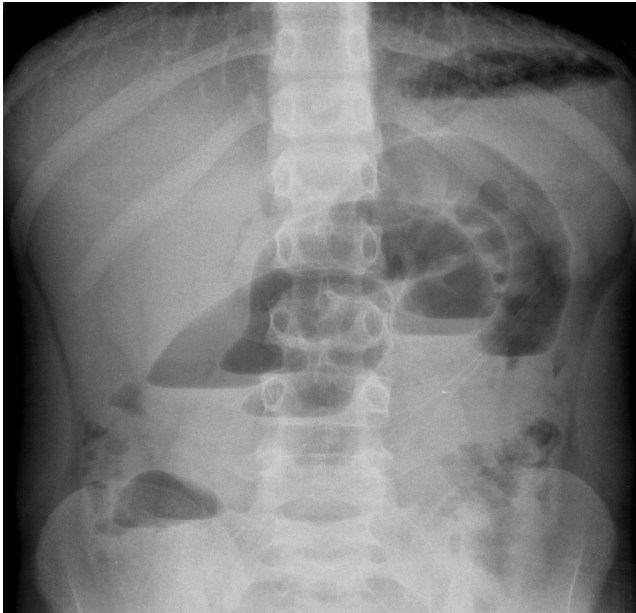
X-ray that shows ileal distension with multiple air fluid levels.
